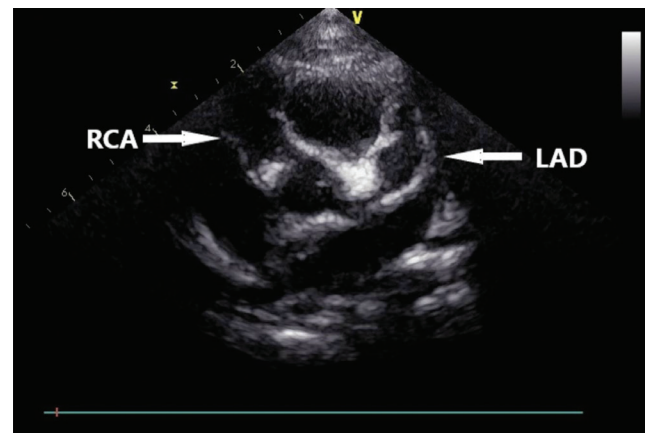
Giant coronary artery aneurysms showed from parasternal short-axis view
